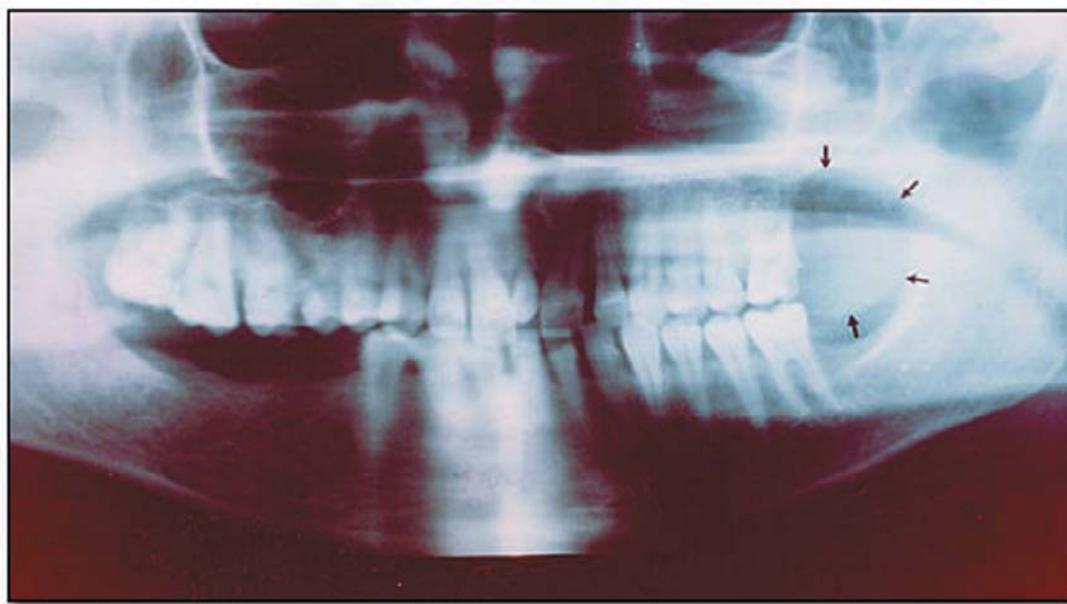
Panoramic radiography of CGCG localized in the maxillary molar area.
